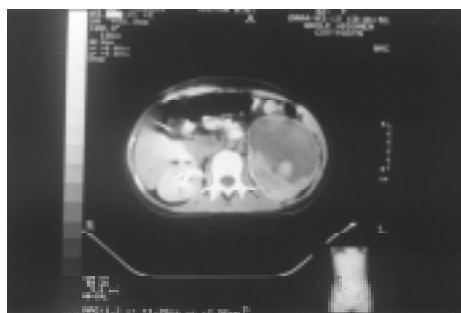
CT Scan abdomen. A huge space occupying lesion in the left Kidney, with mixed echogenicity.
